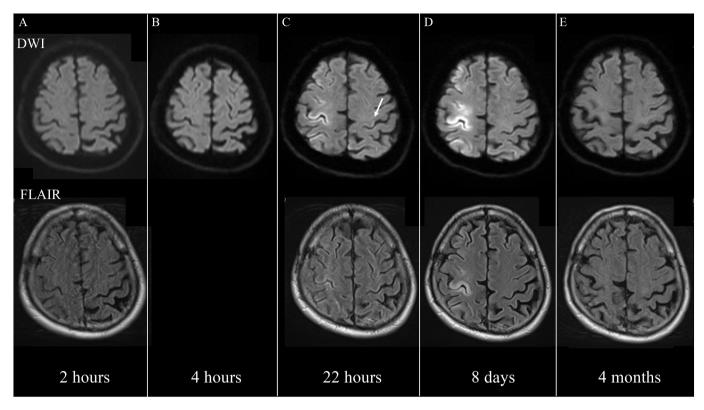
Longitudinal MRI changes (A) DWI and FLAIR 2 h after the procedure. (B) DWI 4 h after the procedure. (C) DWI and FLAIR 22 h after the procedure, showing restricted diffusion affecting cortical areas in bilateral hemispheres. Arrow shows restriction at the precentral gyrus. (D) DWI and FLAIR 8 days after and (E) DWI and FLAIR 4 months after the procedure.
